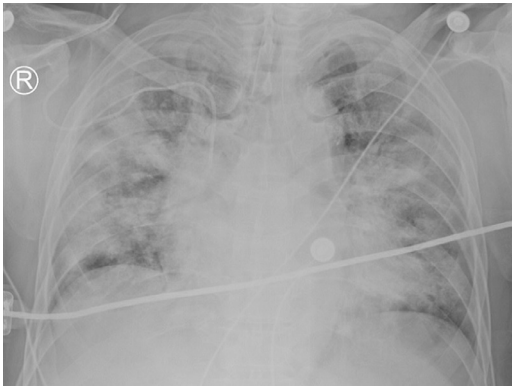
Chest X ray on February 24th. Anteroposterior chest radiograph showed multifocal ground-glass opacities in bilateral lungs, especially the right lung.
